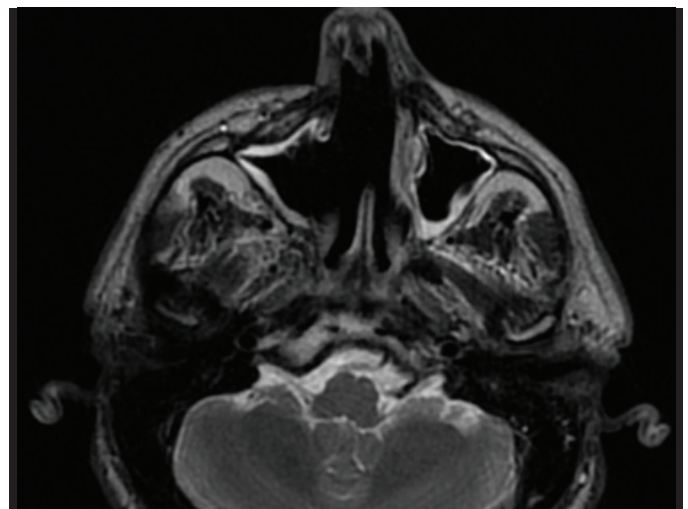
Magnetic resonance imaging at postoperative 6<sup>th</sup> month: mucosal thickness in the cavity of the right maxillary sinus seen on T1 weighted coronal section
